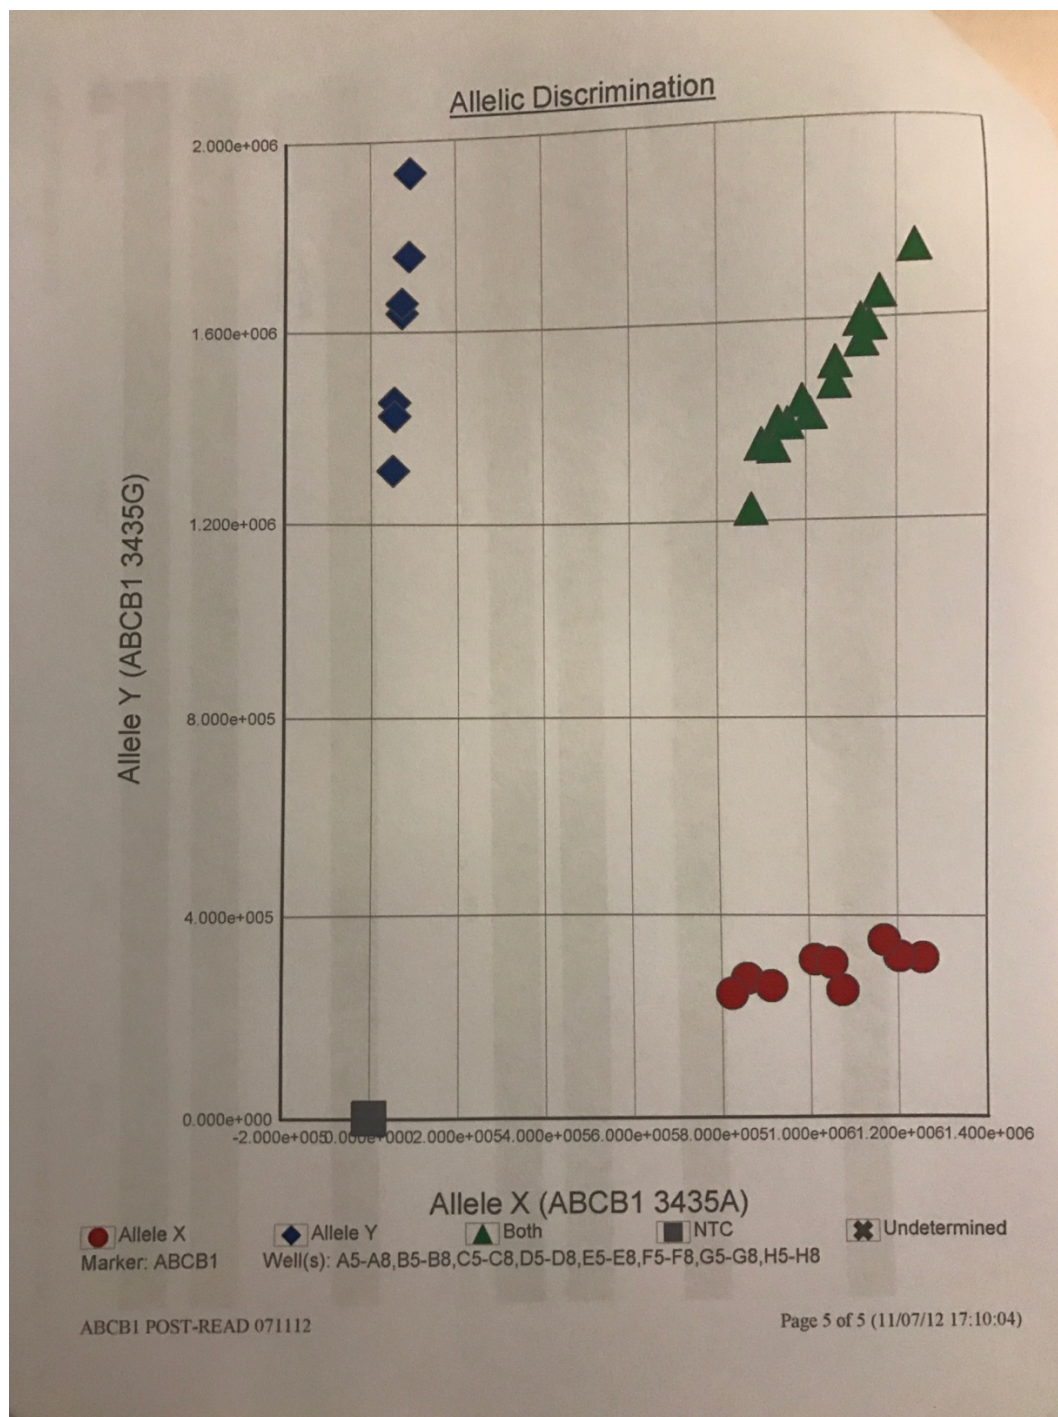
RT-PCR output for ABCB1 Alleles. CC represented by the blue squares, CT by the green triangle and TT by the red dots, again the grey squares are the NTCs.
